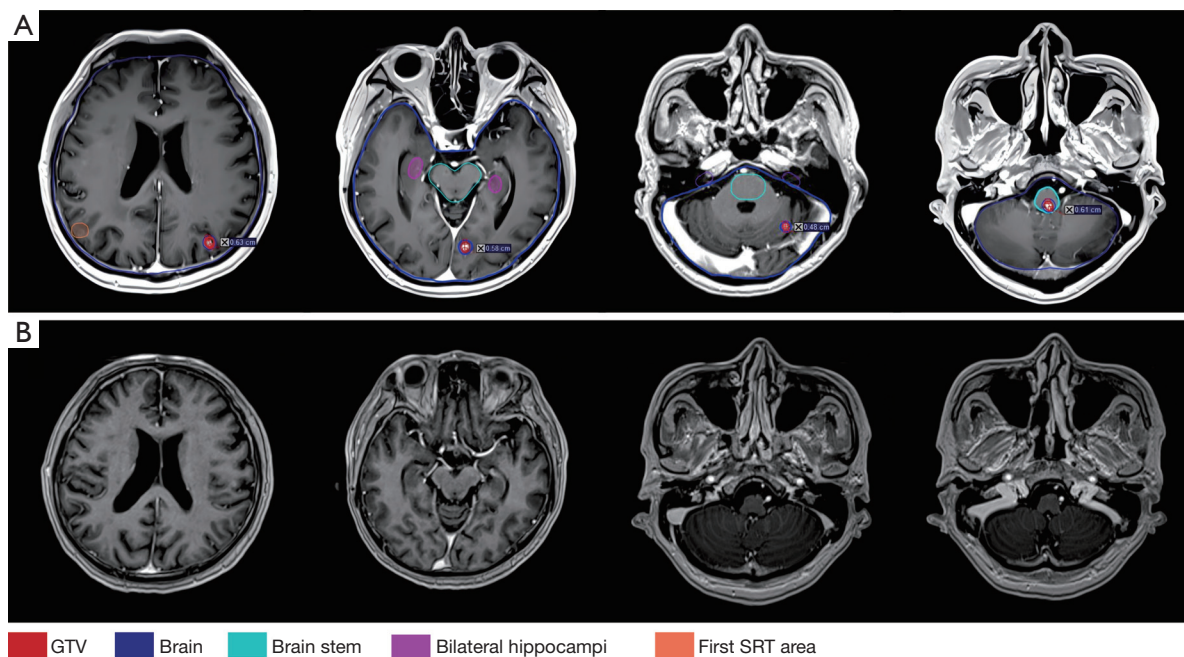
Changes in the 4 lesions after the first recurrence of distant brain failure. (A) The location of GTV and OARs for the second SRT from positioning MRI performed on February 10, 2023. (B) The intracranial lesion distribution on contrast-enhanced MRI performed on February 27, 2023, after the second SRT. GTV, gross tumor volume; SRT, stereotactic radiotherapy; OARs, organs at risk; MRI, magnetic resonance imaging.
